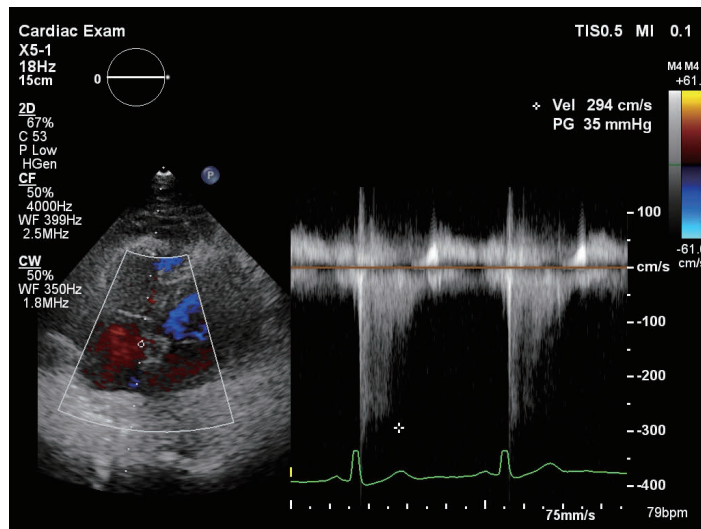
Transthoracic echocardiography on ICU day -3. Continuous-wave Doppler shows a tricuspid regurgitation pressure gradient of 35 mmHg, suggesting pulmonary hypertension.
